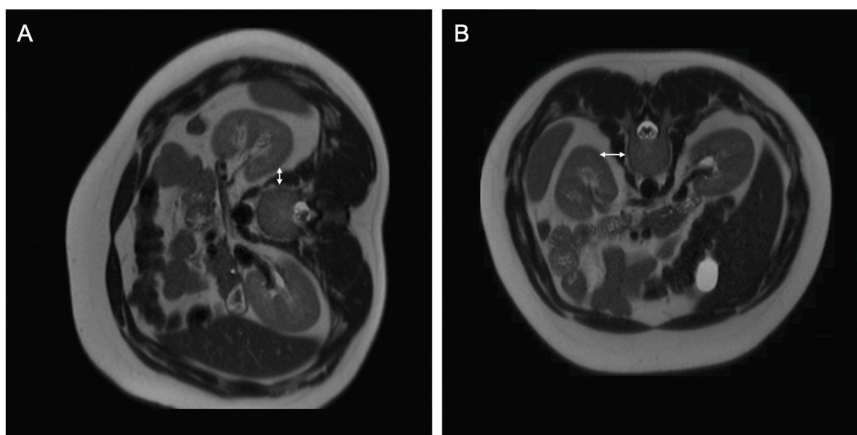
Magnetic resonance imaging scans in the transversal plane at L1 in lateral decubitus position (A) and prone position (B). Arrows demark the measurement from the vertebral body to the first intercepting organ border.
